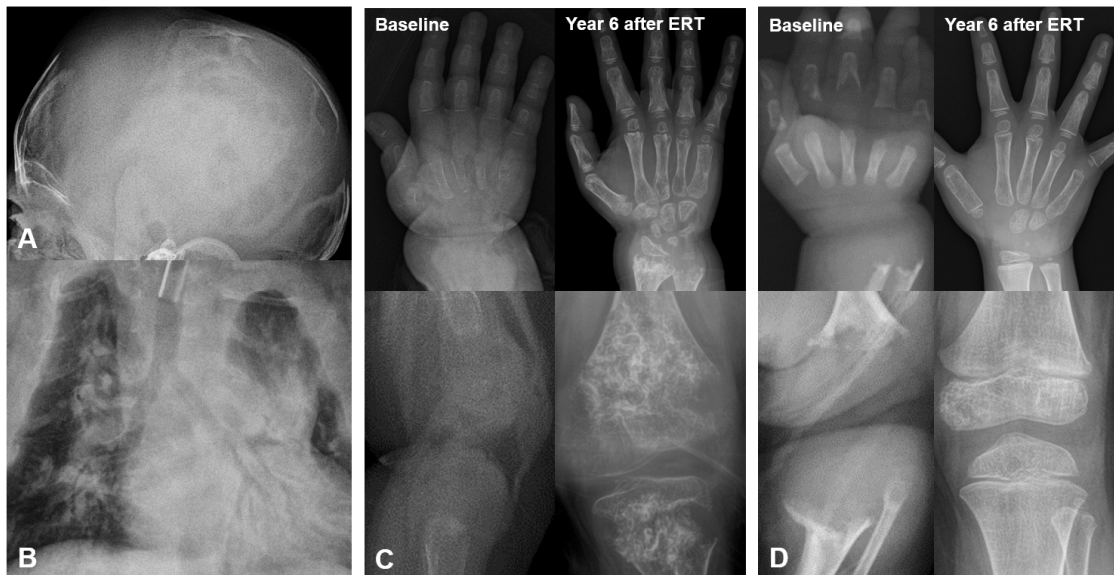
Radiographic findings of patients with hypophosphatasia (HPP). (A), (B), and baseline images of (C) are of a 21-month-old patient with infantile HPP before starting enzyme replacement therapy (ERT). Severe fontanelle widening, thin ribs, irregular osteolytic bone change with metaphyseal fraying in bones of leg, wrist, and hand can be seen. The images in (D) are baseline images before ERT and images after 6 years of ERT in a patient with perinatal lethal HPP who started ERT at 1 month of age. The patient who started ERT earlier showed better skeletal improvement.
